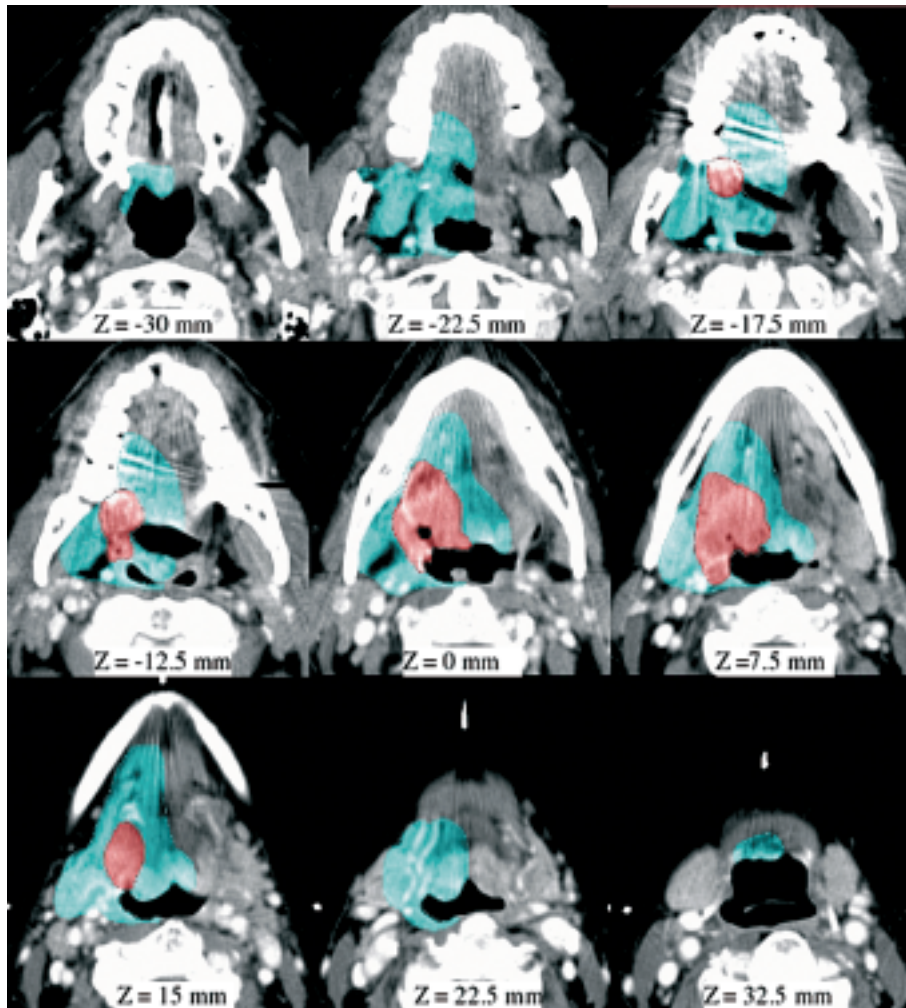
Axial CT slices of a 53y female with a T4 tumor of the right tonsilla (GTV in red) extending through the glossotonsillar sulcus to the base of tongue, the mobile tongue and the floor of the mouth. It laterally extends to the parapharyngeal space through the posterior pharyngeal wall and shows an intimate contact with medial pterygoid muscle and submandibular gland. All of these structures plus the soft palate and the retromolar trigone are included in the CTV (in light blue).
